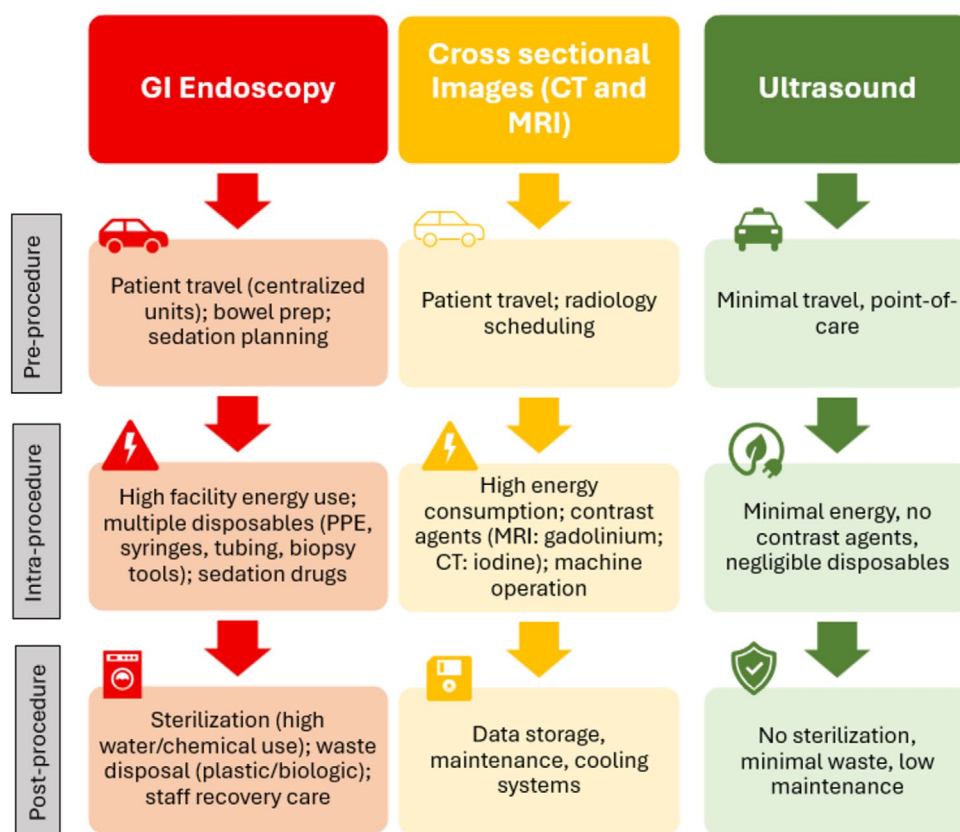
Environmental impact points across diagnostic tools in inflammatory bowel disease (IBD). The figure summarises pre-, intra- and post-procedure contributors to carbon emissions and resource use for endoscopy, cross-sectional imaging (CT and MRI) and ultrasound (US). Endoscopy and cross-sectional imaging are associated with substantial travel, energy consumption, disposables and waste management, whereas US demonstrates minimal energy use, negligible disposables and reduced ancillary infrastructure needs.
